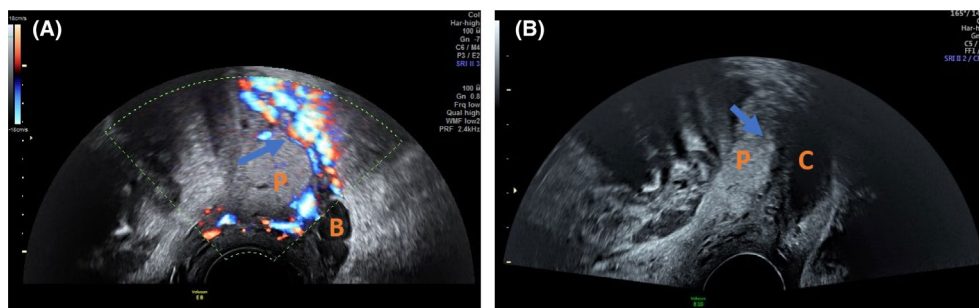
Vaginal ultrasound images showing: (A) Important retroplacental vascularization and (B) placenta previa covering the internal cervical os. B, bladder; C, cervix; P, placenta.
